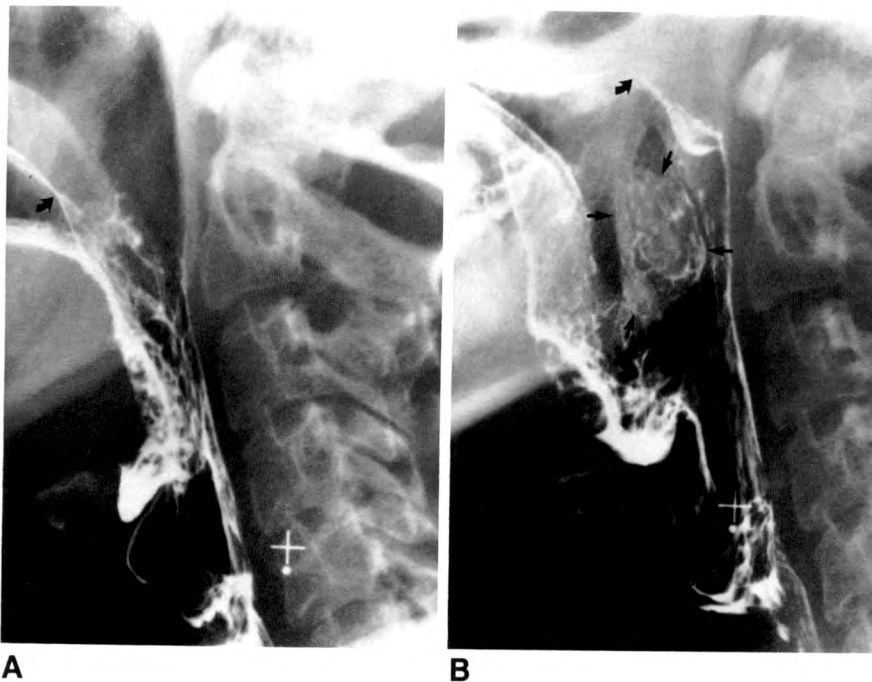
Radiographs in 23-year-old man recently recovered from pharyngitis and presumed to have lymphoid hyperplasia of palatine tonsil.
